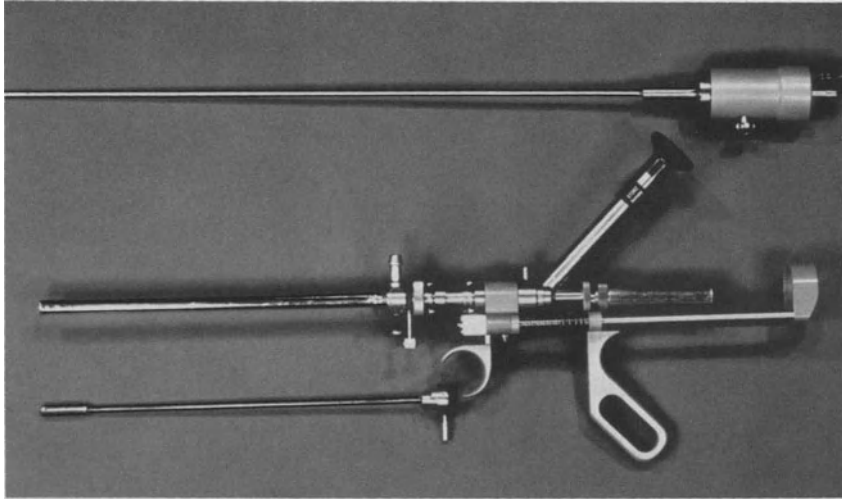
Commercially available cranked cystoscope (center), ultrasound transducer and probe (*above*) and obturator (*below*)
